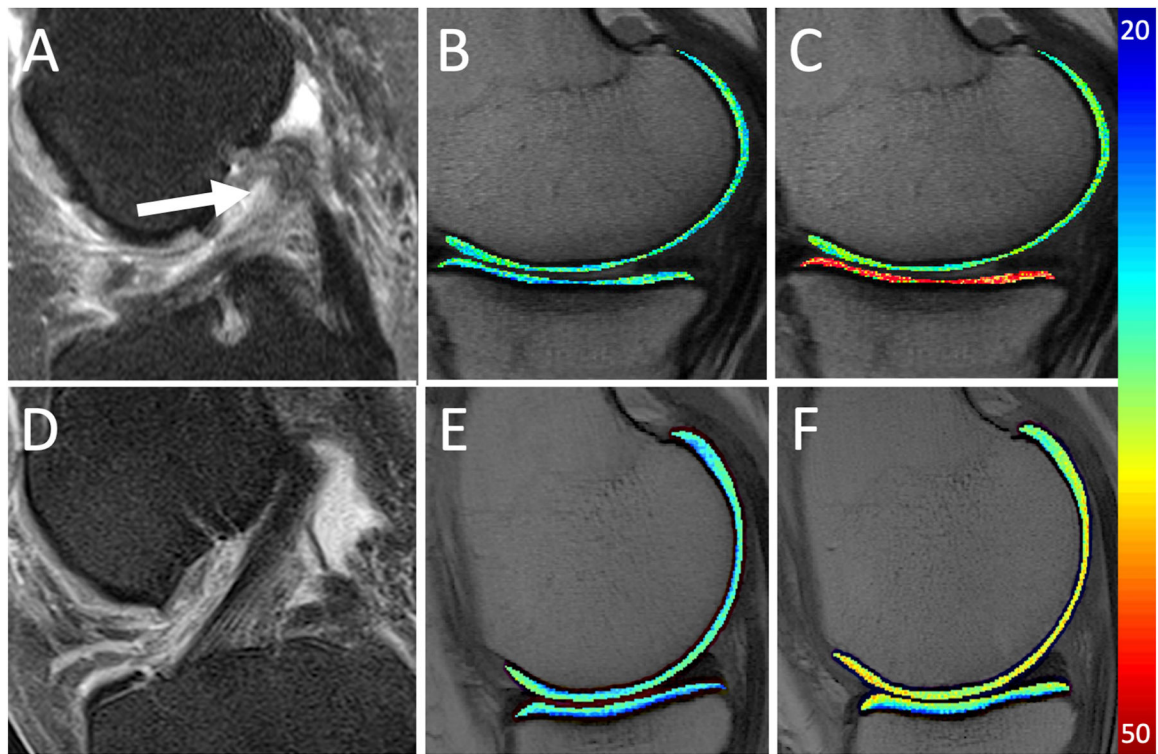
Exemplary MR images and T2-maps of a 52-year old female participant with chronic complete anterior cruciate ligament (ACL) tear at baseline (A, white arrow). T2 maps at baseline (B) and after 8 years (C) showing increase of cartilage T2 values in the medial tibiofemoral compartment (orange and red regions), indicating progression of biochemical cartilage degradation. A 58-year old female with normal ACL (D). T2 maps at baseline (E) and after 8 years (F) showing only a subtle increase of T2-relaxation times in the medial tibiofemoral compartment (yellow regions), suggesting less cartilage progression compared to the participant with chronic ACL tear.
